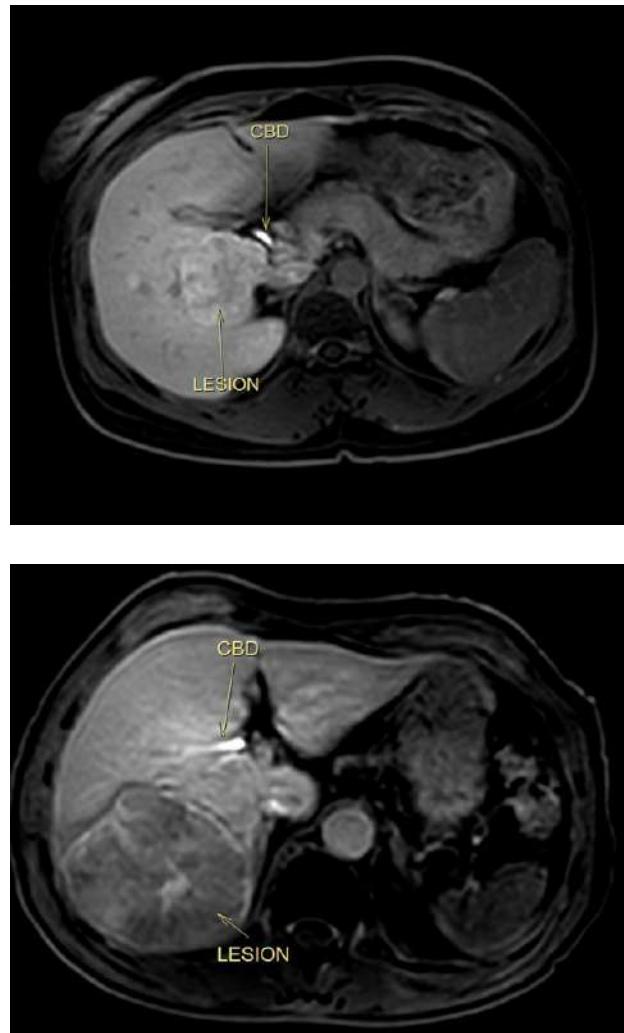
MRI liver (Hepatobiliary contrast) @ 2 hrs – showing the biliary opacification. a) The lesion in posterior segment shows retained contrast thereby representing functioning hepatocytes (FNH). b) The lesion shows washout representing non-functioning hepatocytes (HCC).
